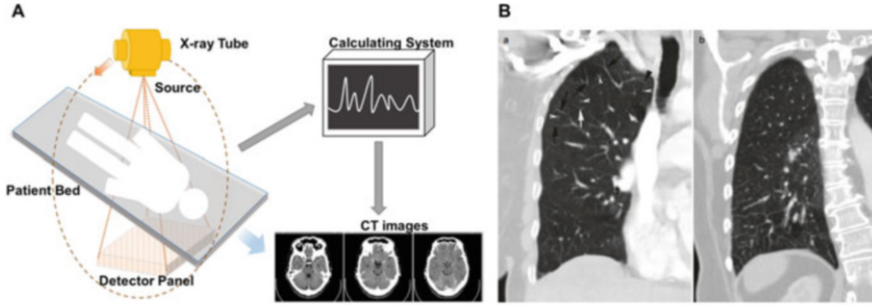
The basic principle of CT scanning and its typical applications. (a) The simplified process of a CT scan. Electric signals acquired from the scanning machine which contains the structural information of the patient would be translated to several flat images by customized computer systems. (b) Different features can be observed in CT images of a normal lung *(a)* and the lung of a patient with lymphangitic spread of cancer and thickening of the interlobular septa *(b)* for cancer diagnosis
